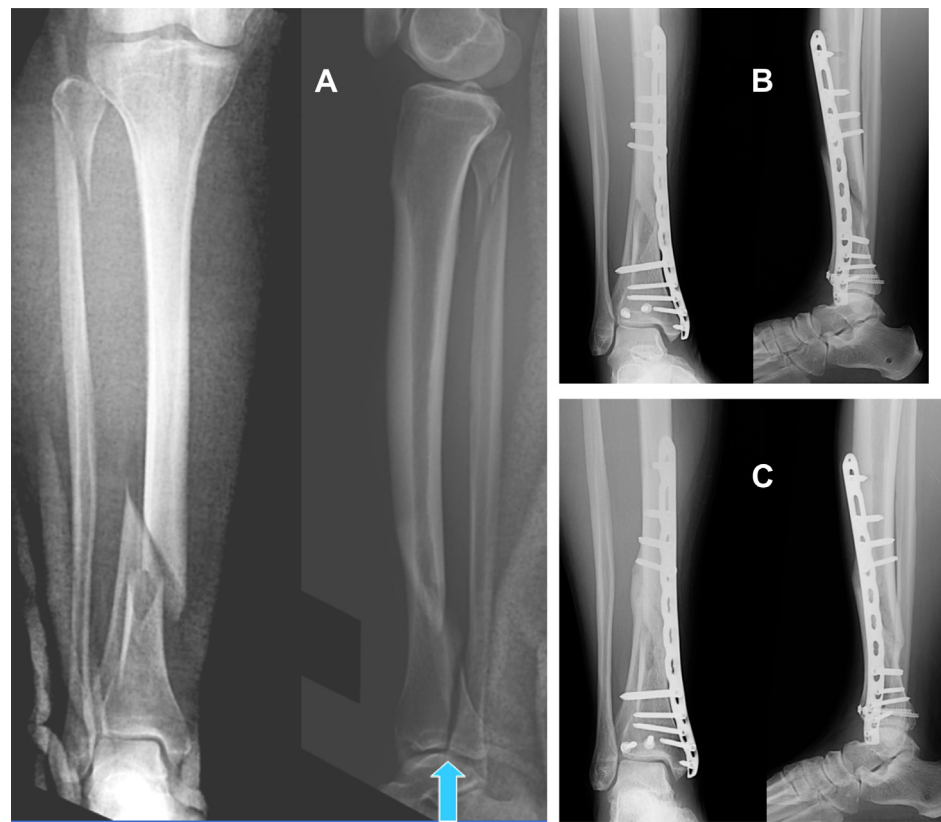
(A) Plain films for a 49-year-old female who suffered a motorcycle accident leading to a right tibia shaft fracture with concomitant posterior malleolar fracture (PMF). There was also a proximal fibula fracture. Note the displaced PMF fragment on the lateral view (arrow). (B) The patient underwent open reduction and internal fixation with a plate and screws. The PMF was reduced and then fixed with two screws. The proximal fibula fracture was treated nonsurgically. (C) Five months after the surgery, solid union of both the tibia shaft fracture and the PMF was observed. The proximal fibula fracture was also healed.
